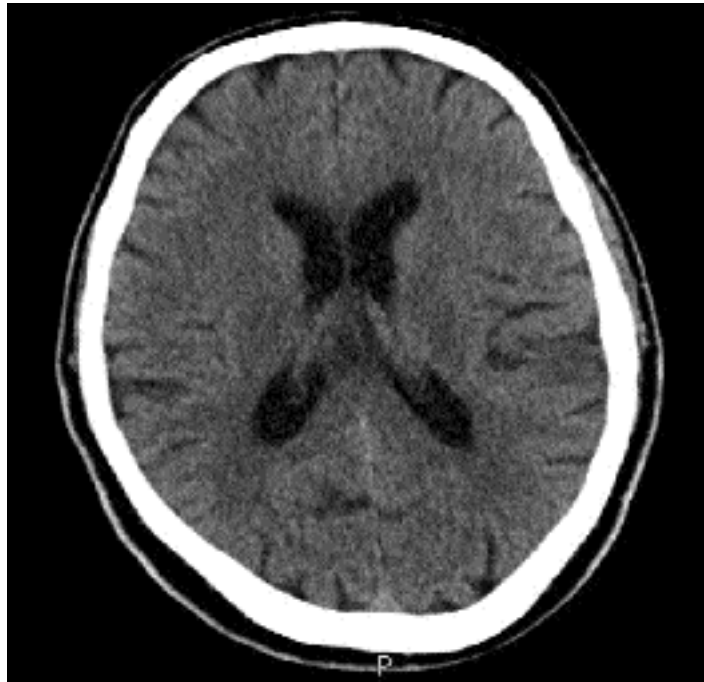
CT scan of brain with no abnormal lesion (Naqi and Azeemuddin 2013)
